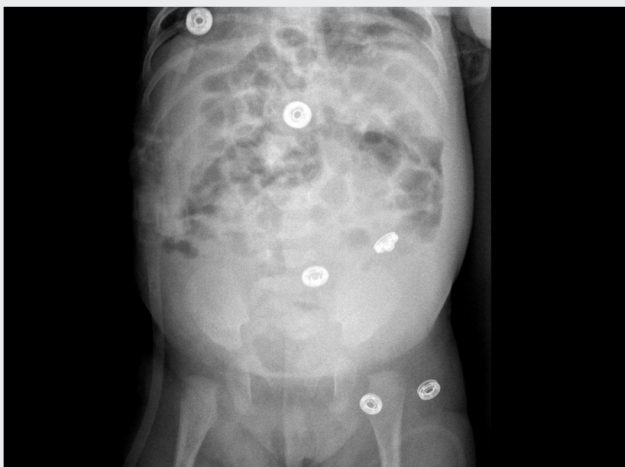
Patient's direct abdominal X-ray, taken after surgery demonstrating disappearance of abdominal mass
